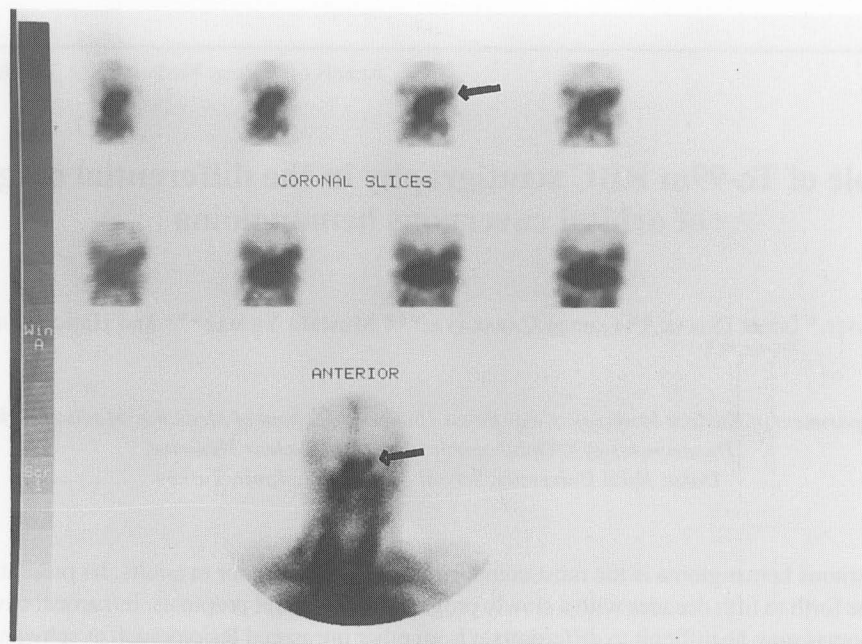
In coronal slices and delayed blood pool anterior image of the head, Tc-99m RBC scintigraphy revealed increased uptake in the lesion (arrow).
